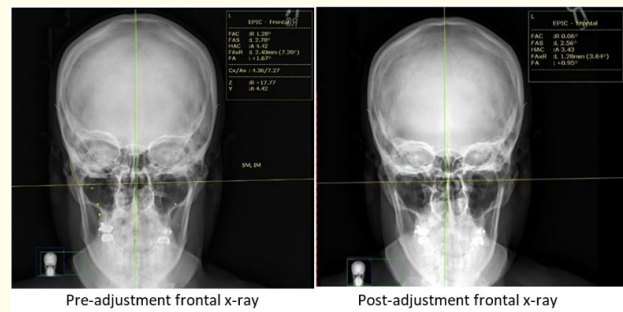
Comparison of pre and post adjustment radiographic findings.
